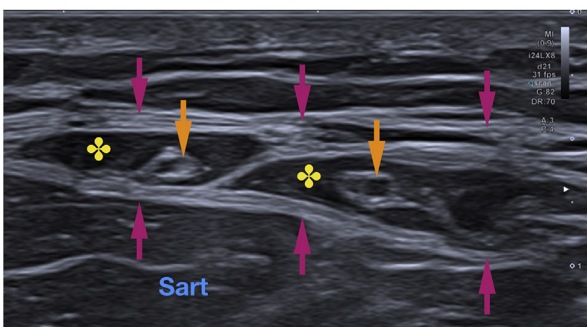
A 24 MHz sonogram of the thigh clearly shows branches of the lateral femoral cutaneous nerve (golden arrows) within fat-filled fascial tunnels (yellow asterisks) in-between different layers of the fascia lata (magenta arrows). Sart: sartorius muscle.
